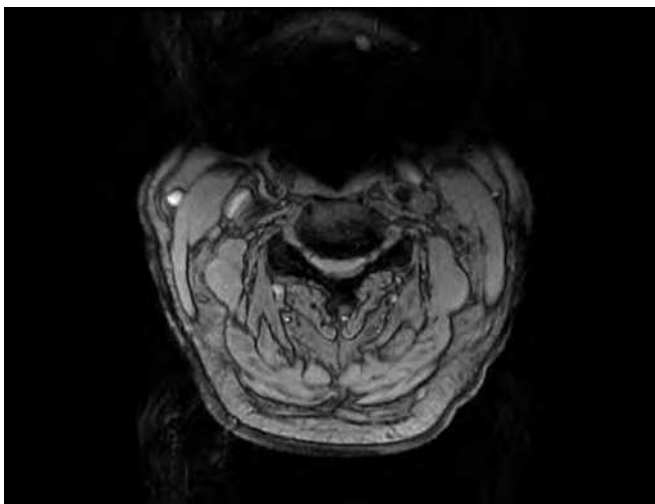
Axial MRI at C3 level: severe central stenosis with effacement of CSF and spinal cord compression (MRI: Magnetic resonance imaging; CSF: Cerebrospinal fluid).
